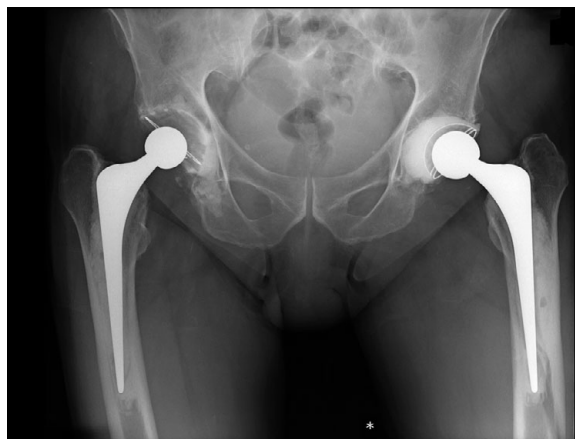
Anteroposterior (AP) radiograph left hip
